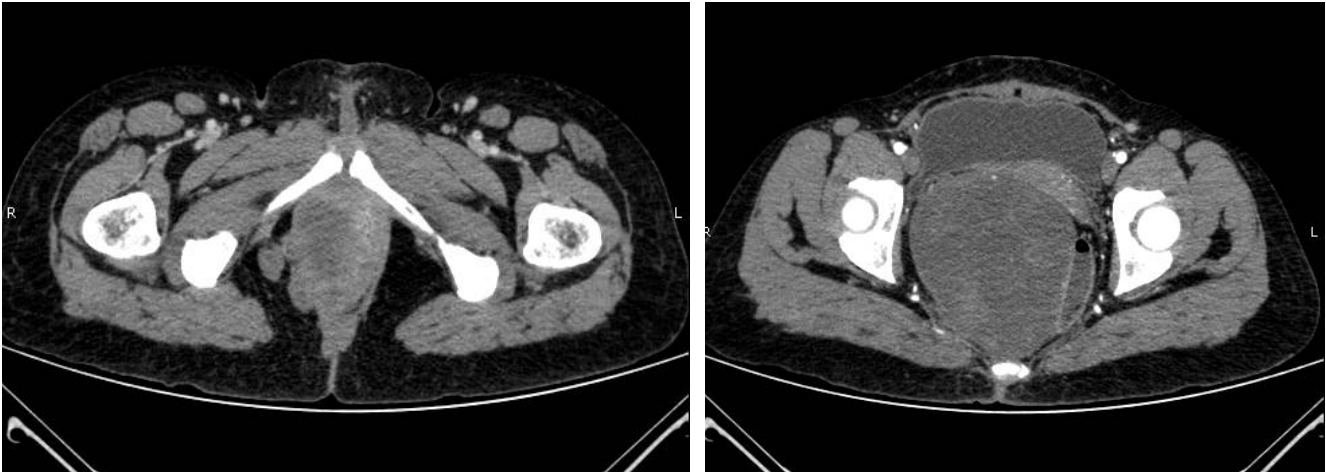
Contrast enhanced computed tomography showed inhomogeneous mass in pouch of douglas. This mass was seen arising out of right vaginal wall and was causing displacement of rectum. At the level of perineum this mass was at right paravaginal region and was seen extending into gluteal fat.
